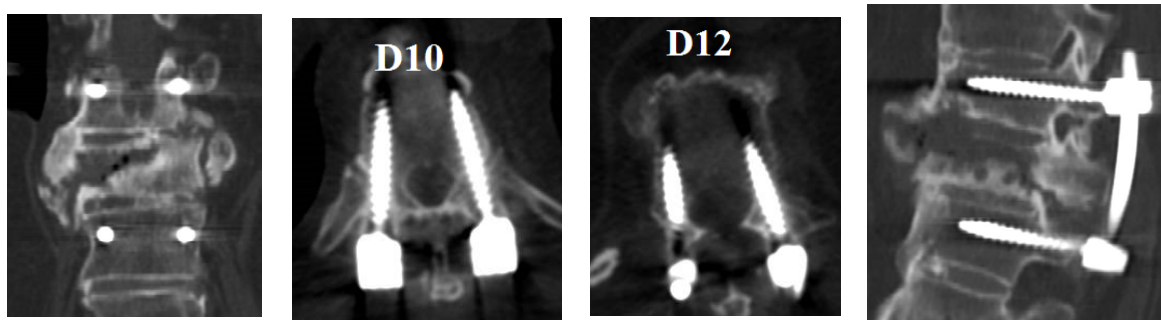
CT 12 months after the operation, with coronal, axial and sagittal reconstructions: a worsening of the kyphosis level registered before the operation as well as a further restriction of the vertebral canal are excluded.
